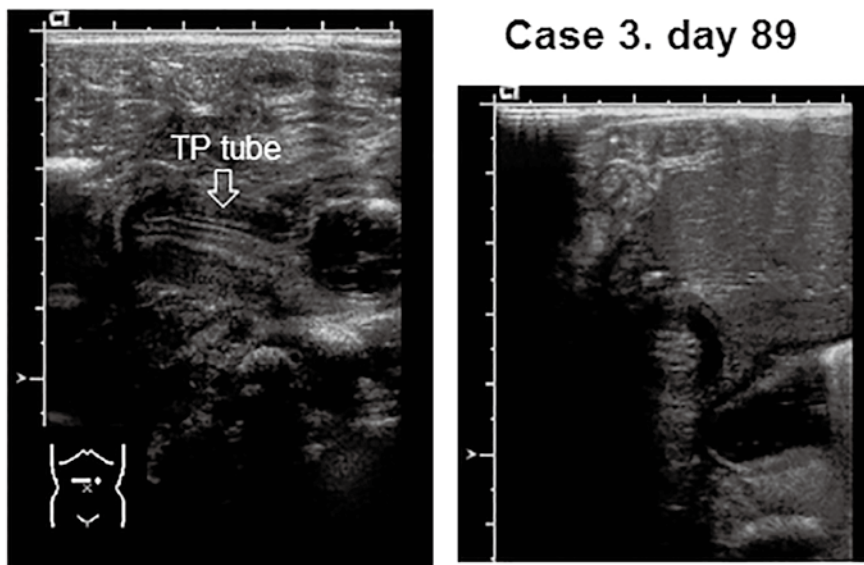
Ultrasound showed a hypertrophied pylorus. The pyloric muscle thickness was 6.6 mm, the canal length was 20.1 mm, and the canal diameter was 13.6 mm.
